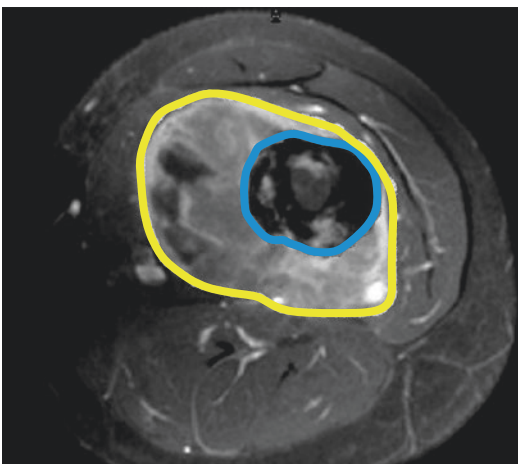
Ewing's sarcoma. Axial fat-suppressed T2-weighted MR image demonstrating the size of both the bone (blue) and soft tissue components (yellow) of the lesion
